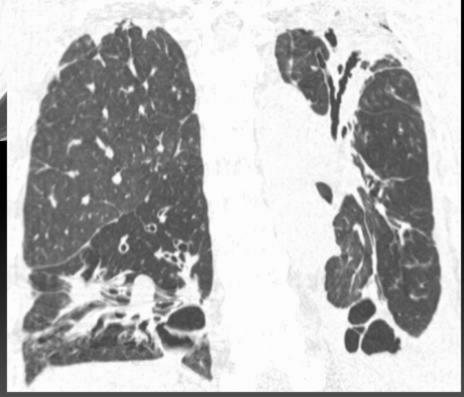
In the same patient, thoracic CT shows bilateral thin-walled cystic lesions corresponding to cavities and cystic bronchiectasis. There are also cylindrical bronchiectasis in the left upper lobe and pleural thickening.
